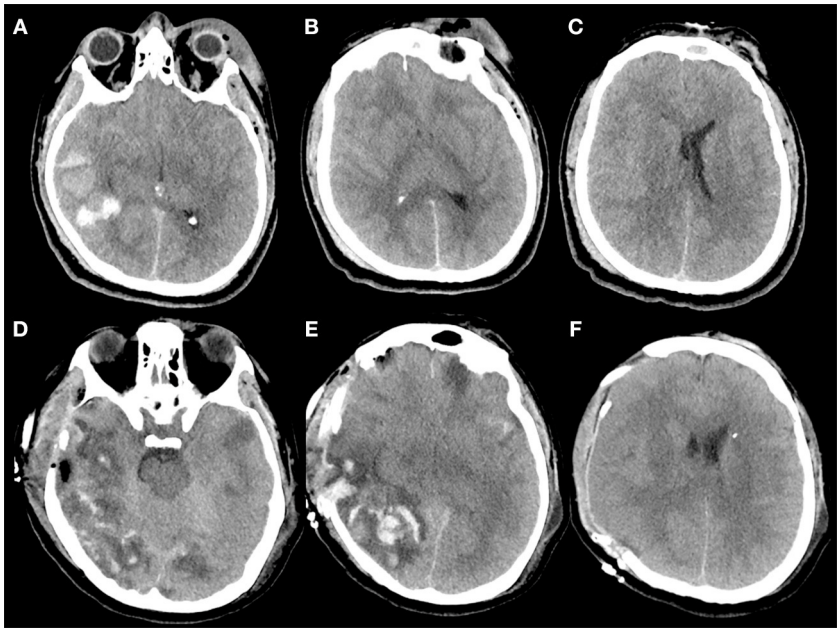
(A–F) Example of contusion expansion in a 35-year-old patient who underwent to DC for uncontrollable high ICP secondary to brain swelling and temporal hemorrhagic contusion with total volume > 20 cc. The patient sustained a polytrauma with TBI after intentional precipitation and 3 h after trauma was admitted at our hospital with a Glasgow Coma Scale score of 4 (E1V1M2) and was put under mechanical ventilation. The pupils were bilaterally equal and reactive. (A–C) (Pre-operative CT scan) Pre-operative CT scan, immediately performed after admission of the patient described above, showing a right temporal post-traumatic hemorrhage with total volume > 20 cc (A), diffuse brain swelling (B), and left midline shift (C); after this CT, an intraparenchymal probe for ICP monitoring was placed on the right side with stable values of ICP up to 30 mm Hg despite maximal medical treatment. Then the patient was immediately operated and a right DC was performed. During surgery, no active bleeding was observed at the level of temporal contusion and for this reason no lobectomy was performed. (D–F) (Post-operative CT scan) Post-operative CT scan performed 1 h after surgery demonstrating massive contusion expansion (D,E) and initial herniation of the brain away from the craniectomy defect (F).
